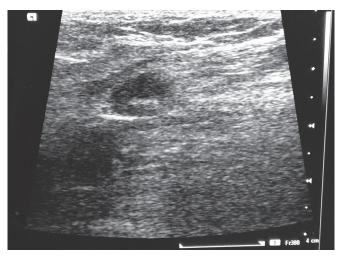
Gray scale ultrasonography showing small normal-sized lymph node with normal nodal architecture and central hilum
